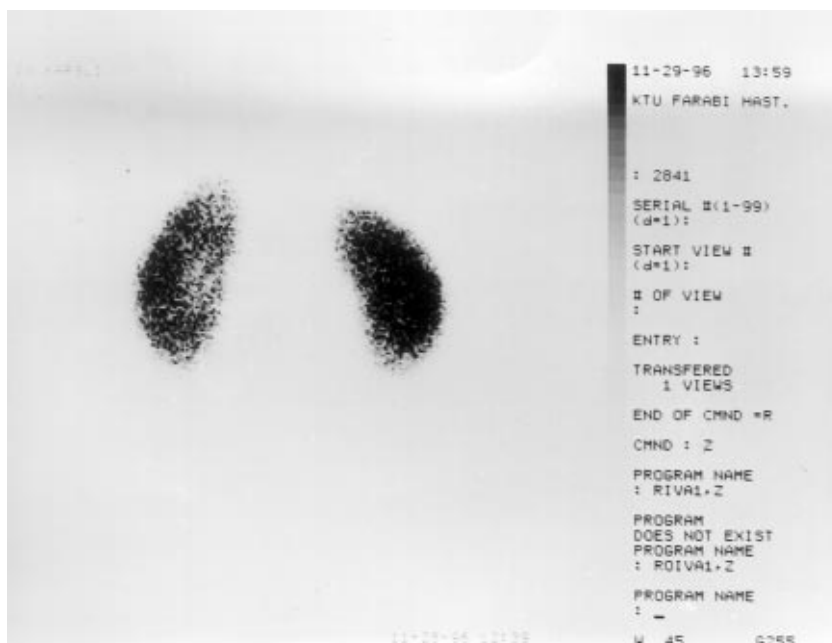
Renal scintigraphy shows marked cortical uptake defects.
